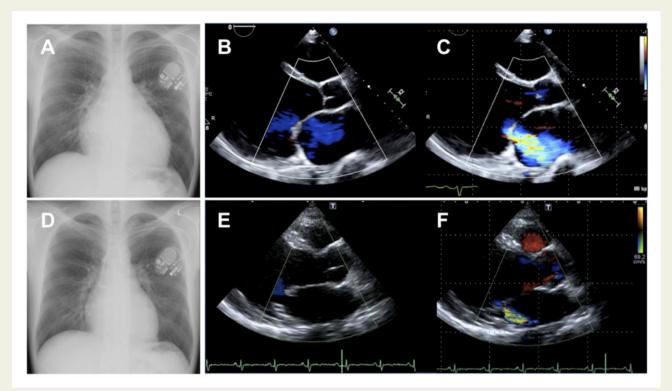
Chronological changes on the radiograph (A and D) and echocardiography of parasternal long-axis views in diastole (B and E) and systole (C and F) before (December 2019) and 10 months after (October 2020) motivational interviewing. Significant improvements in terms of cardiomegaly, left ventricular function, and mitral regurgitation after 10 months of motivational interviewing.
